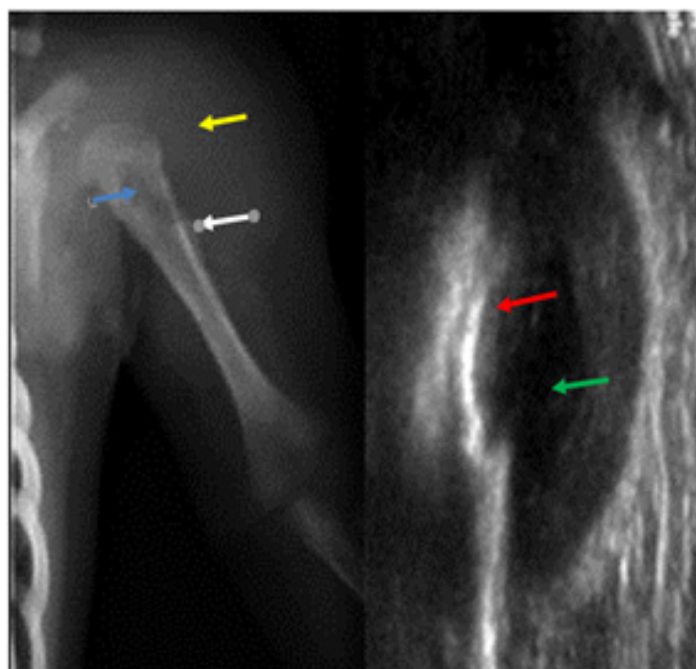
24-month-old infant, upper left humeral metaphyseal AOM on D15. A (X-ray): lacuna (blue arrow), periosteal apposition (→), densification of the soft tissues (→); B (Echography): hypoechoic collection under periosteum, (→), cortical gap (→).
